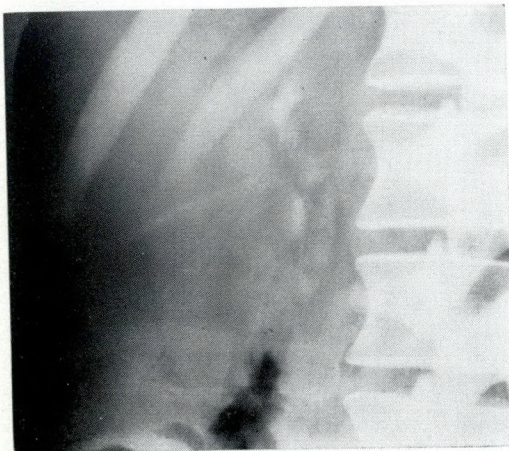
Post cholecystectomy. Radiograph shows stones in the common bile duct.
